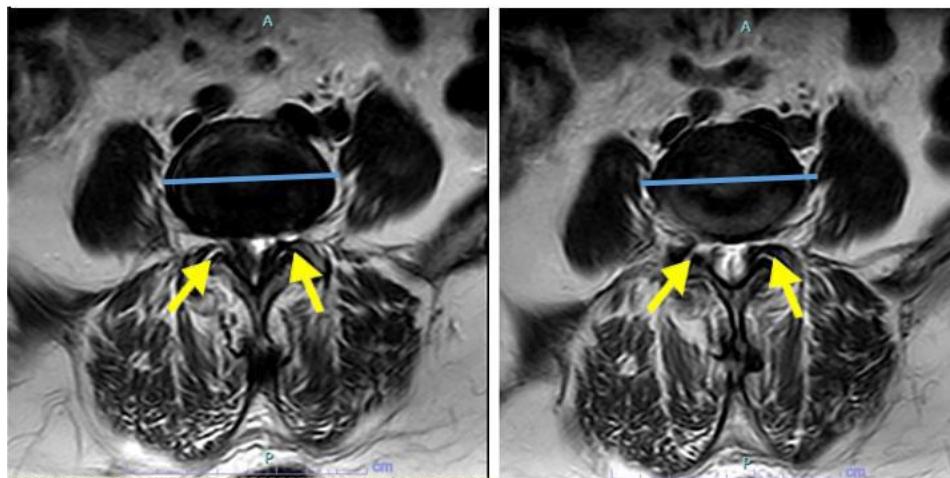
MRI Sequence (eAx_T2_TSE) blue marking signifies posterior broad-based protrusion along with yellow arrows indicating significant narrowing of bilateral neural foramina.
